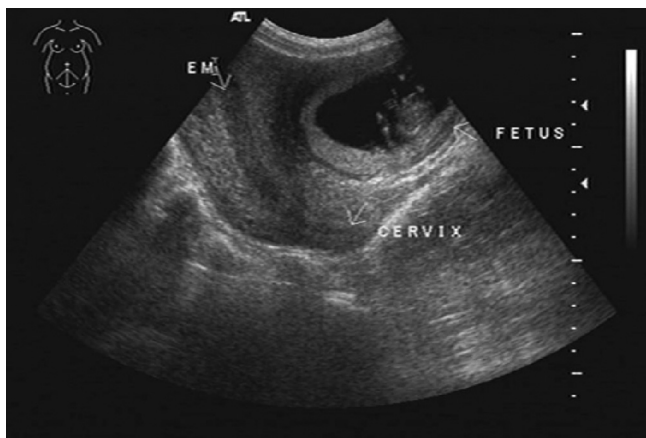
A rudimentary horn pregnancy was suspected under sonography.
